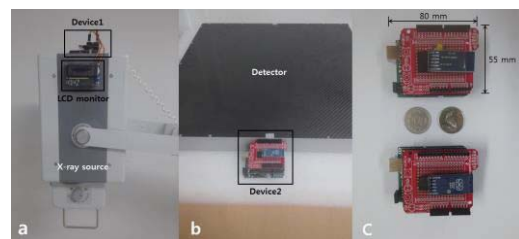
The details of developed devices on X-ray source(a) and detector (b), and its actual size (c)
